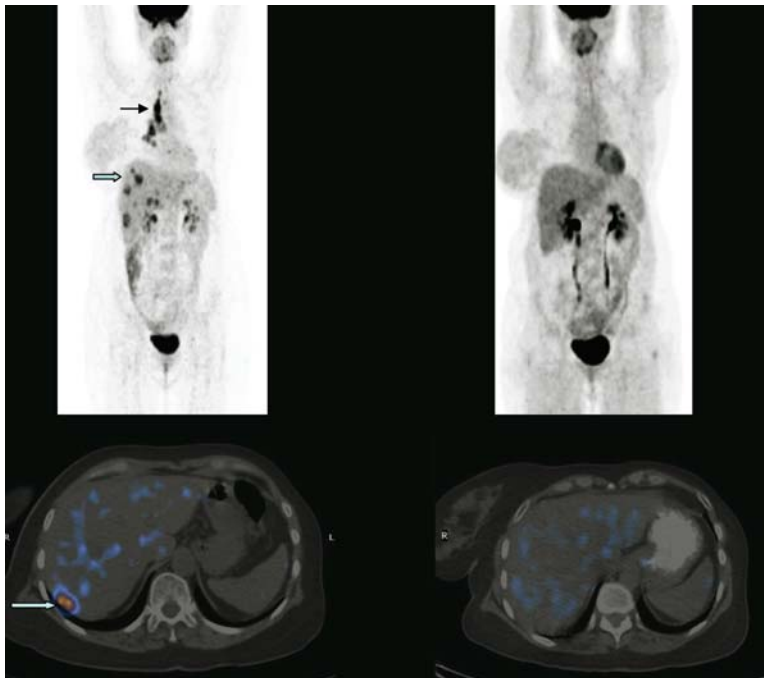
A 50-year-old patient, 6 years after left mastectomy and adjuvant chemo- and radiotherapy due to breast carcinoma, referred with elevated serum Ca 15.3 and negative CT of the chest, abdomen and pelvis. Maximum-intensity-projection PET (upper left) image and a PET/CT transaxial image of the liver (lower left) show FDG avid disease in the mediastinum (left arrow) and liver (blue arrow).
